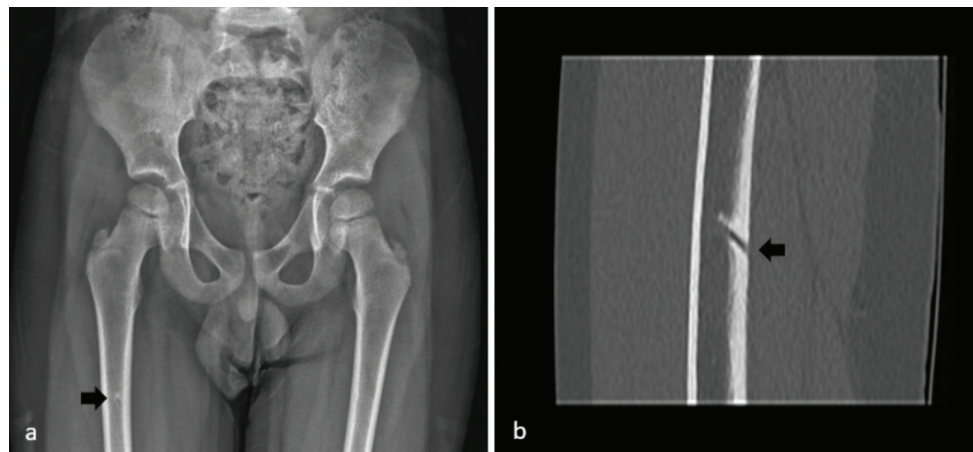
Femur's nutrient artery canal. a. Pelvic anteroposterior graph shows a lytic lesion at the diaphysis of the right femur (arrow). b. A sagittal non-contrast computed tomography scan shows the hypodense line of the nutrient artery entry (arrow) and canal course from the cortex to the medullary part of the femur.
